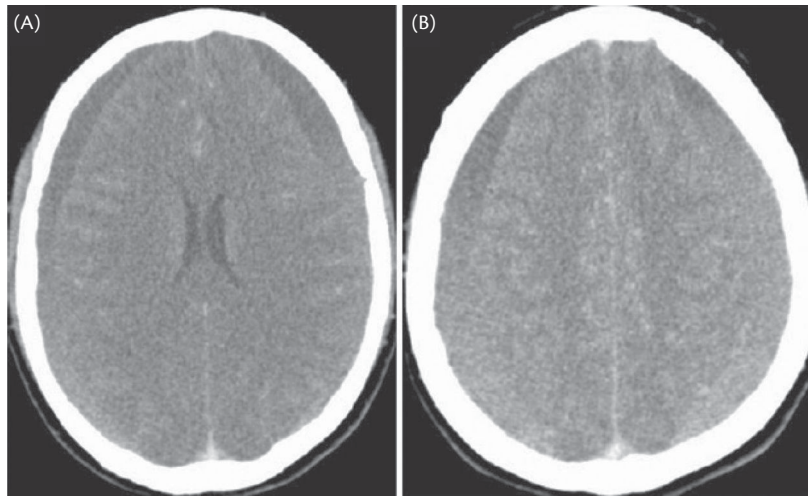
CT brain scan showing large bilateral isodense chronic subdural haematomas with (A) lateral ventricle compression, and (B) significant mass effect on brain parenchyma.
